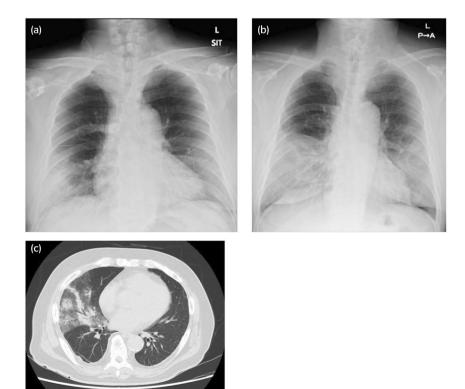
The patient's chest radiographs (x-rays) and CT images on POD 6 and 9. (a) Chest x-ray on POD 6 reveals reduced right lower lung field permeability. (b) Chest x-ray on POD 9 reveals that the decreased permeability in the right lower lung field had worsened over the last 3 days. (c) Chest CT on POD 9 reveals a mixture of reticular and infiltrating shadows demarcated from the surrounding area.
